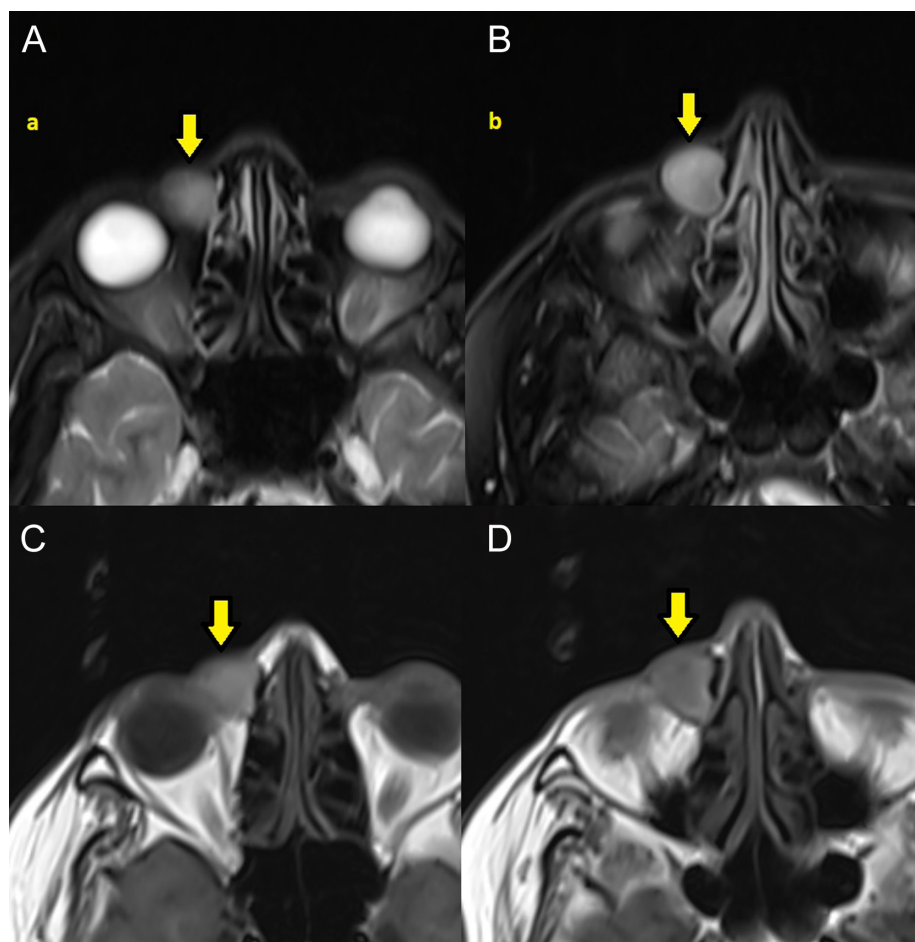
Axial plane T2-weighted (A, B) and axial plane T1-weighted magnetic resonance images (C, D) of the dacryocystocele (yellow arrows).
